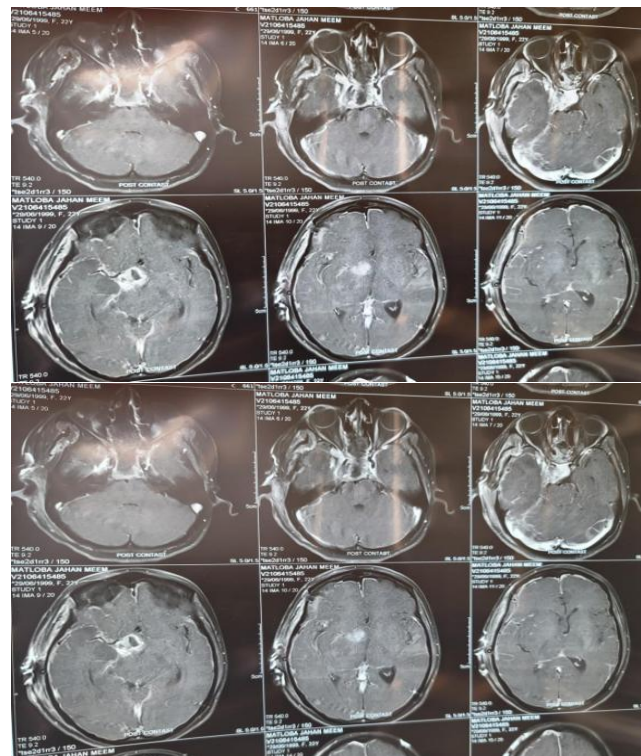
MRI showed lobulated enhancing lesion (2.5×1.6×2 cm) in the sphenoid region with mild right cavernous sinus encasing right ICA; residual reduced as compared to previous scan. Mild compression of optic chiasma and right optic nerve was still present.
